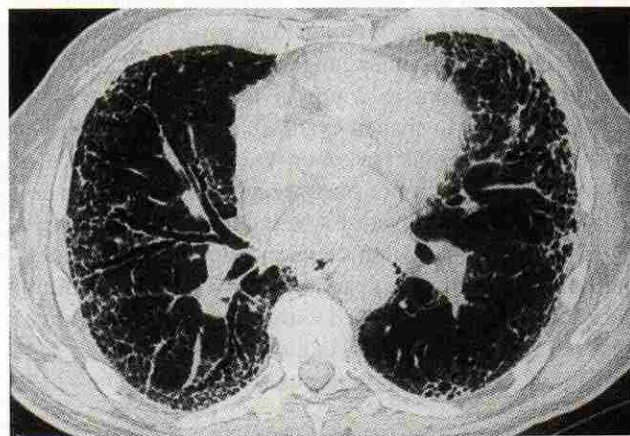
High-resolution computed tomogram of patient with idiopathic pulmonary fibrosis (usual interstitial pneumonia). Note thin-walled cystic process in the lung periphery. There is also traction bronchiectasis consistent with a long-standing fibrotic process. This patient had a basilar distribution of this cystic disease, which is characteristic of usual interstitial pneumonia. From Ryu et al.<sup>67</sup>
